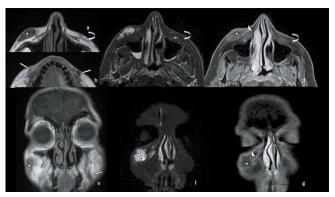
Craniofacial MRI of the patient, four years after surgical removal of the largest inflammatory nodule and lipofilling of the hypotrophic defect. a) Axial T1 Upper cut at malar level; b) Axial T1 lower cut at the level of dental arch; c) Axial T2 Fat-Sat; d) Axial T1 Fat-sat with gadolinium, e) Coronal T1; f) Coronal T2 Fat-Sat; e) Coronal T1 Fat-sat with gadolinium. Star: collection of subcutaneous material in the right malar/zygomatic area. Curved arrow: trabecular subcutaneous fat at the left malar. Straight arrow: two-sided material of left predominance. Arrowhead: collection on the right cheek with peripheral contrast when administering gadolinium.
